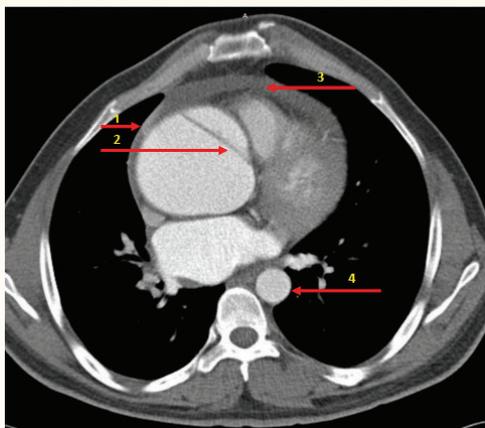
Axial computed tomography (CT) image through ascending (AA) and descending (DA) thoracic aorta showing the aneurysmal dilatation of the ascending aorta (top-right arrow) with intimal flap (type A dissection, top-left arrow) and pericardial effusion (middle arrow). Compare the diameter of ascending aorta with descending aorta (bottom arrow).
